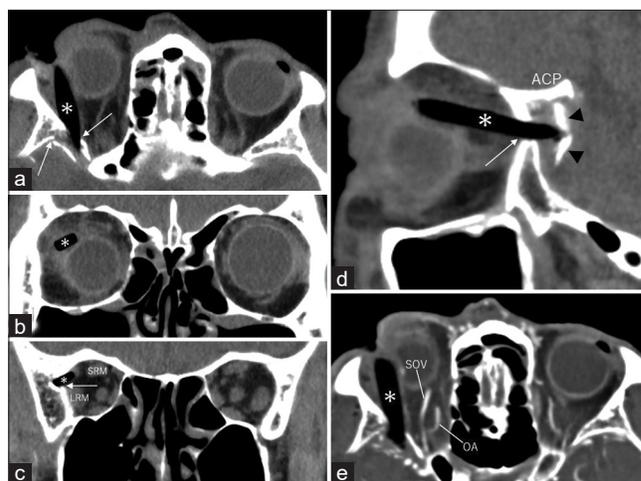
Non-contrast axial (a), coronal at the equator level of the bulb (b) and orbital apex (c), and sagittal (d) computed tomography, 3 mm in slice thickness, show a homogeneously hypodense, linear structure located in the upper lateral sector of the orbit, partially protruding into the middle fossa. Contrast-enhanced axial computed tomography revealed the ophthalmic artery (OA) and superior ophthalmic vein (SOV) to be intact (e). ACP: Anterior clinoid process, LRM: Lateral rectus muscle, SRM: Superior rectus muscle, Arrow: Fracture in the sphenoid bone, Arrowheads: Displaced inner table of the sphenoid bone, Asterisk: Broken shoji frame.
